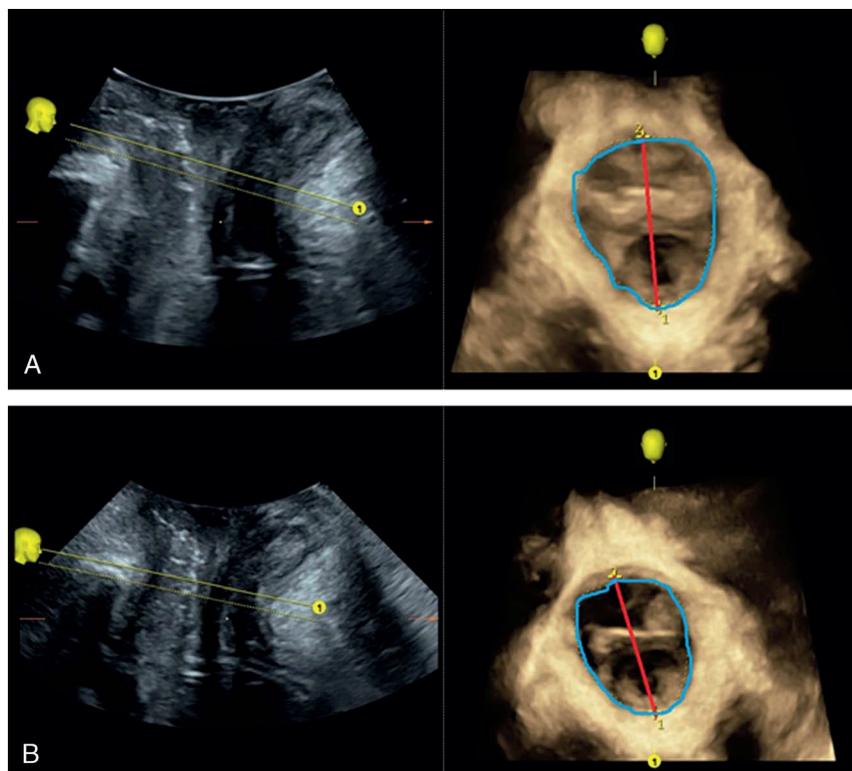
A 39-year-old patient, 1 childbirth. Visualization of ultrasound measurements (Voluson E10, equipped with RIC6-12-D transducer) before (A) and after (B) HIFEM treatments. Midsagittal plane on the left, axial rendered volume on the right. Red line indicates LH-AD dimensions. Area of HA is bordered by blue line. Direction of view in 3D is indicated by yellow lines and a mark.
